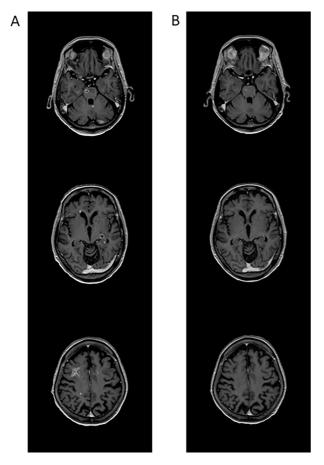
MRI of the brain showing a dramatic response of metastatic brain lesions to dacomitinib treatment. (A) Brain metastasis before dacomitinib treatment (B) The metastatic brain lesions were reduced in size after 2 months of dacomitinib treatment.
